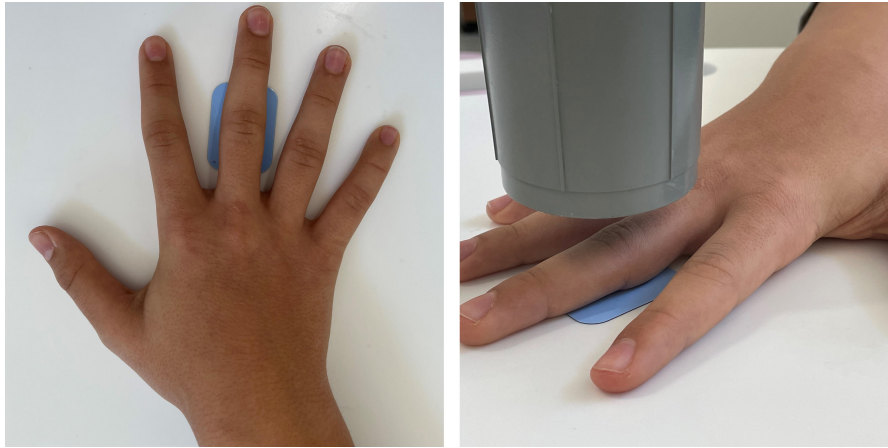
Exact position of the patient's hand to perform a X-ray of the middle phalanx of the third finger.
